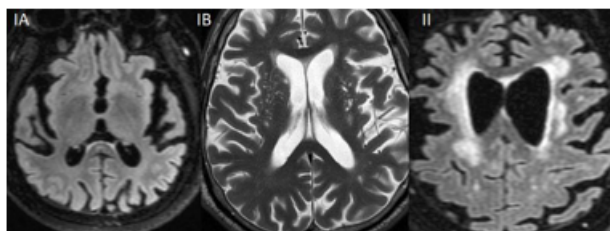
71 year old patient with galloping neurodegenerative lesions; IA=Moderate cortico-subcortical cerebral atrophy associated with millimeter lesions in hypersensitive T2, FLAIR, discrete hyposeminal T1 located in the supratentorial white matter, with no tendency to confluence suggestive of non-specific degenerative vascular lesions (Fazekas 1 score); IB=Diffuse brain atrophy in combination with atrophy of the corpus callosum; II=Cortico-subcortical atrophy over and subtentorial associated with FLAIR, T2 confluent hyperstimulation lesions, located in diffuse white, periventricular and hemispheric bilayer, suggestive modifications of Fazekas III arteriosclerosis.
